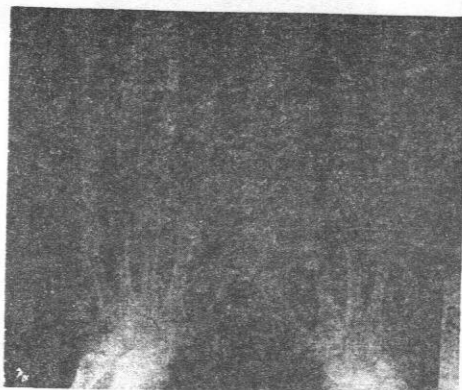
Plain x-ray both hands showing small erosions along the medial aspect of middle phalanx of the 2nd and 3rd fingers.
